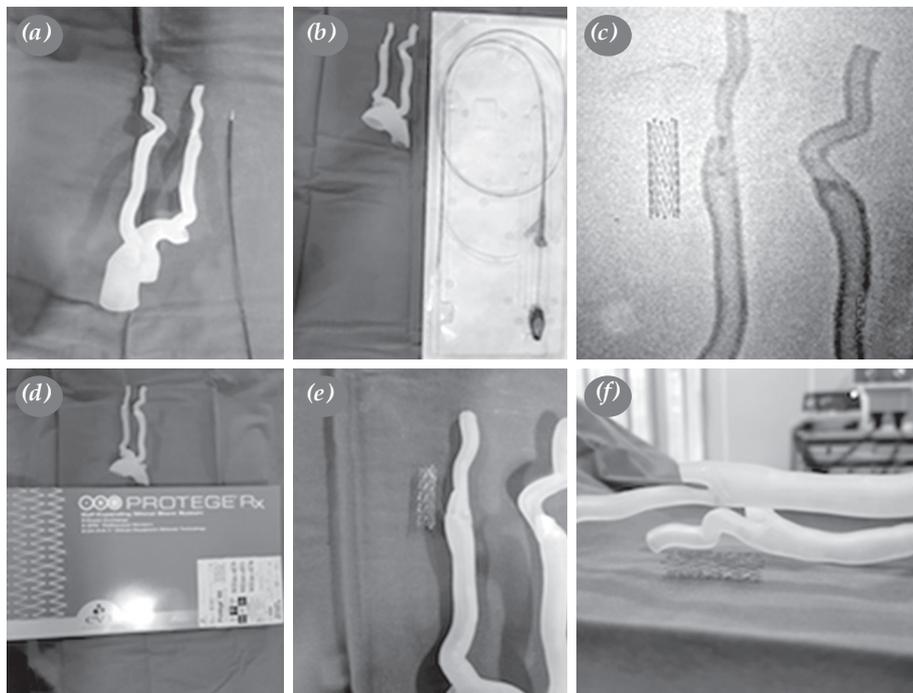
Manual practice with different size of embolic protection device, catheters, wires and stents on 3D physical models in both non-sterile environment and under X-ray tube. (a) Practice with different size of embolic protection device in non-sterile environment. (b) Practice with different size of embolic protection devices and stents in non-sterile environment. (c) Image of carotid stent and 3D digital model under angiographic image. (d) Practice with Protégé stent. (e) Practice with Protégé stent in antero-posterior view. (f) Practice with Protégé stent in lateral view.
